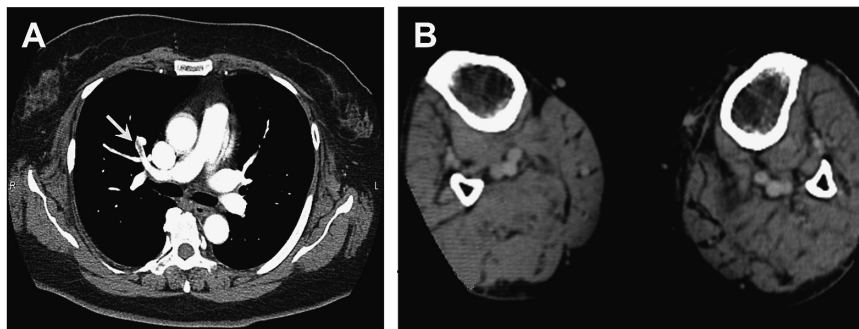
A 57-year-old woman underwent initial total knee arthroplasty due to right knee osteoarthritis. Contrast-enhanced computed tomography was performed 6 days after surgery. A, Thrombosis was detected in the segmental branches of the right pulmonary artery (arrow); B, No thrombosis was evident in the femur or veins of the lower extremity.
